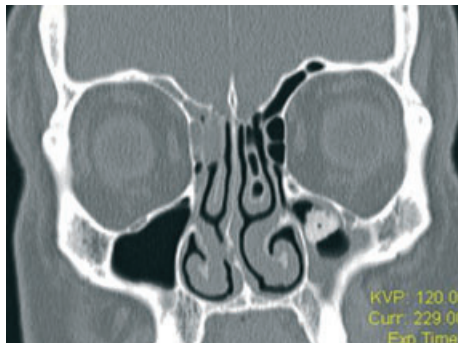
Chronic maxillary sinusitis of dental origin in coronal CT scan. Note endo-antral odontic material migrating towards maxillary natural ostium.
